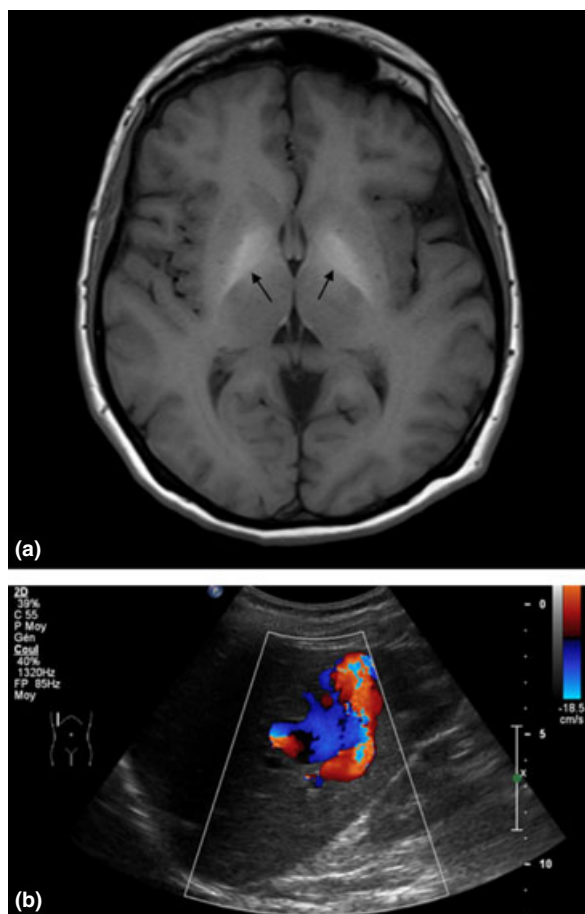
(a) Cerebral MRI showing marked symmetrical pallidal hyperintensities (arrows) on T1 sequences. (b) Hepatic color-coded Doppler ultrasound demonstrating a massive intrahepatic portosystemic shunt.
